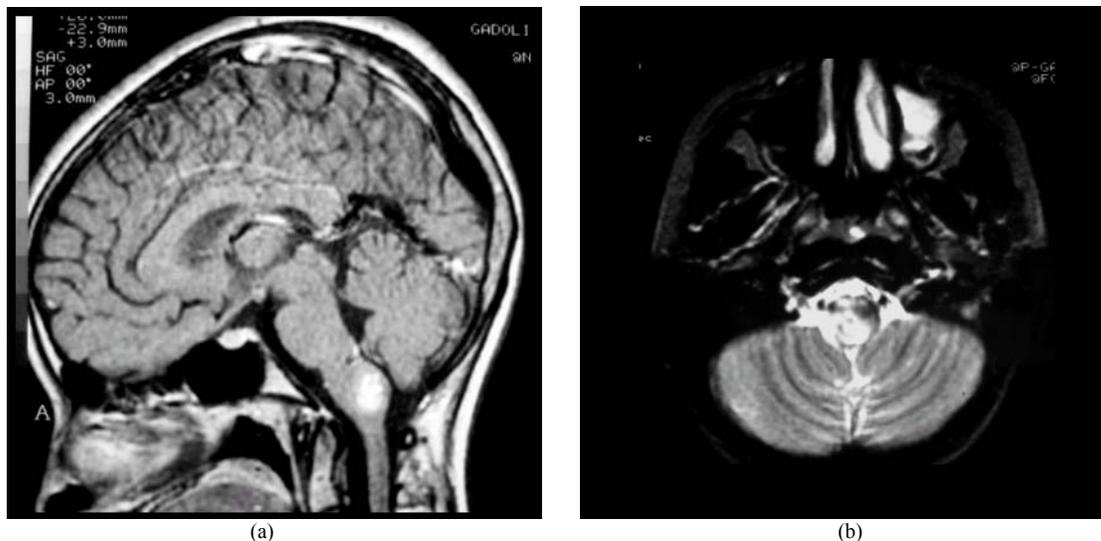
(a): Sagittal T1-weighted showing a gadolinium-enhanced lesion in the medulla in the case 8 (low-grade astrocytoma). (b): T2-weighted MRI showing a focal mass in the medulla and which was a low-grade astrocytoma (case 8).
